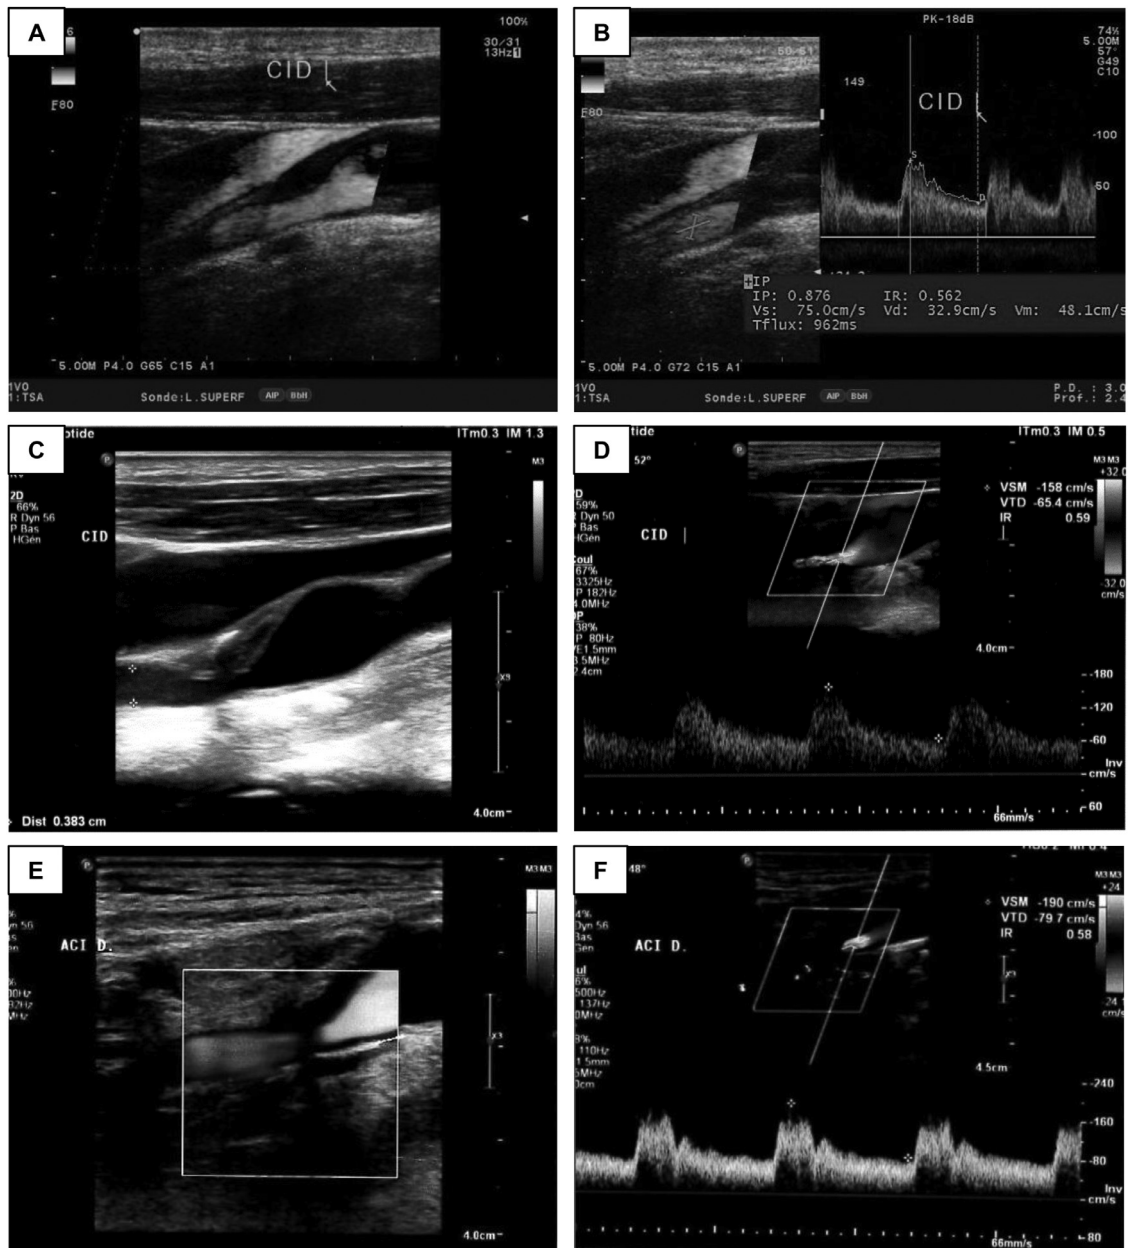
Doppler ultrasonography pictures of the right intern carotid showing the evolution of stenosis at diagnosis (August 2014, A and B), after one year (May 2015, C and D) and before endarterectomy (February 2017, E and F). The thrombosis of right intern carotid was estimated at around 10–30% at first examination (A), evolved to almost 50% after one year (C), then progressed to 70% (E), which was the indication for a surgical intervention. If this stenosis had no consequences on flow velocity at first discovery (75 cm/s, B), it rapidly evolved to an increase of this parameter above the pathological threshold of 125 cm/s (158 cm/s at 50% stenosis, D, and 190 cm/s at 70% stenosis, F).
